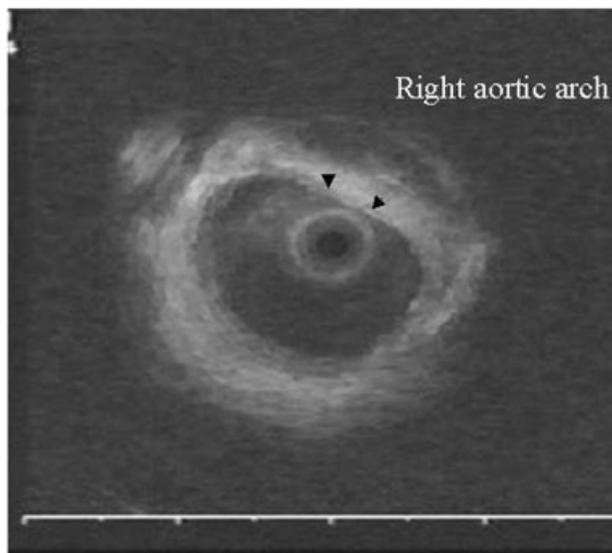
Endobronchial ultrasound demonstrating destruction of the hypoechoic cartilaginous layer of the tracheal wall (arrows) at the site of compression by right aortic arch.
